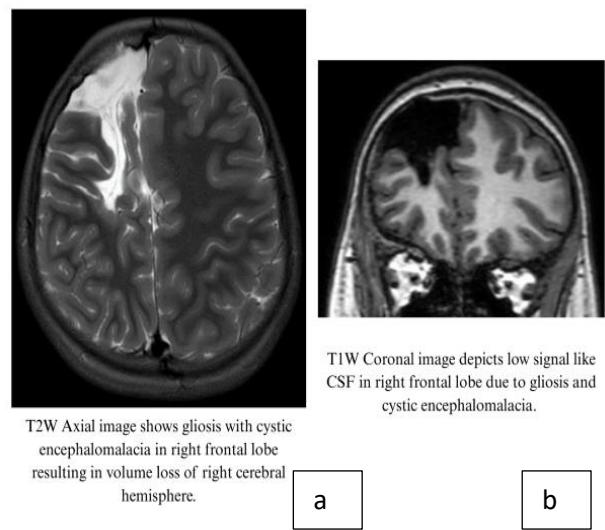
(a and b): MRI showing cystic encephalomalacia and volume loss on right cerebral hemisphere.
